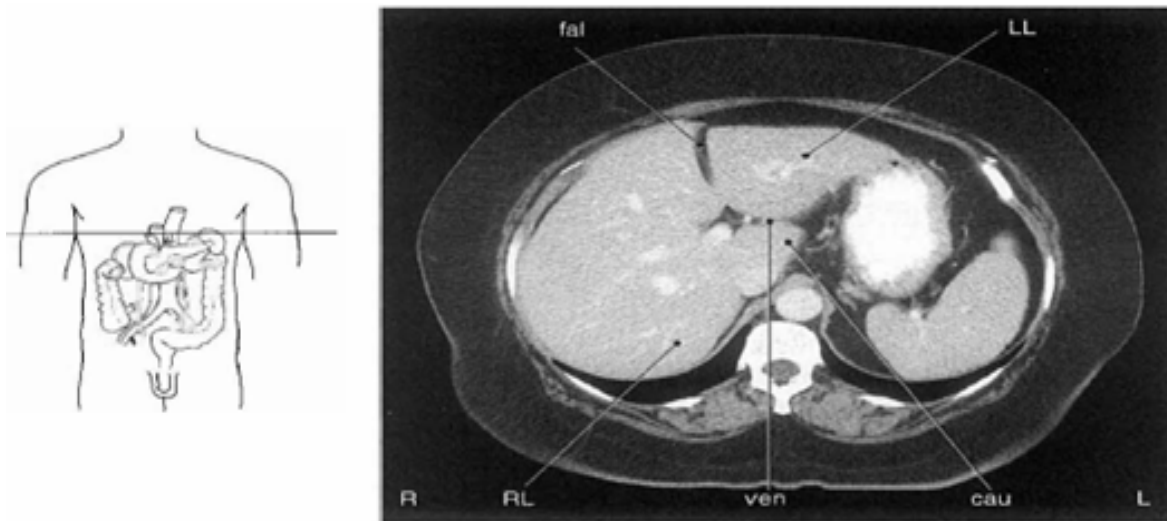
CT scans through caudate lobe.
